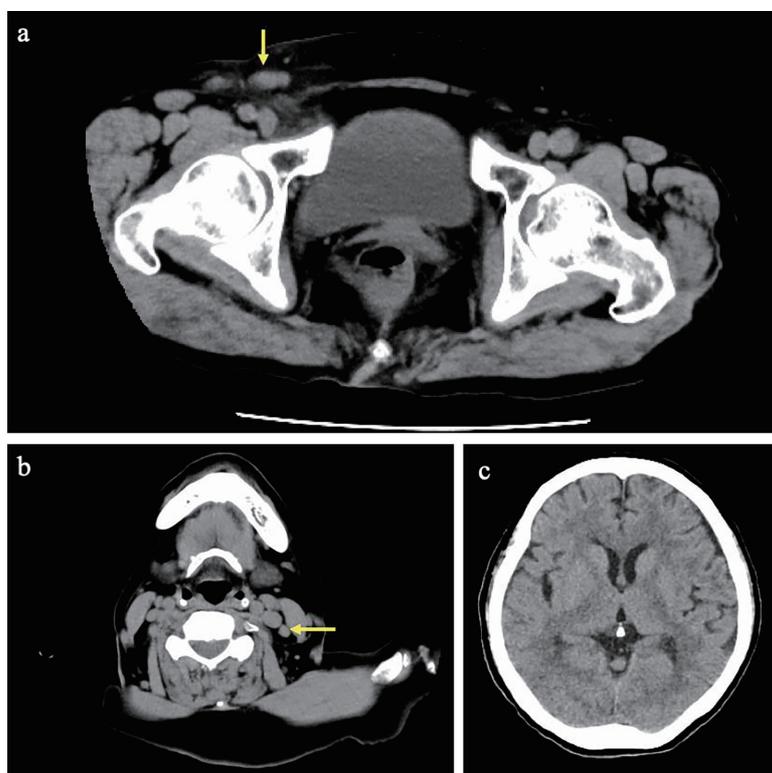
Images of computed tomography (CT) on admission.
